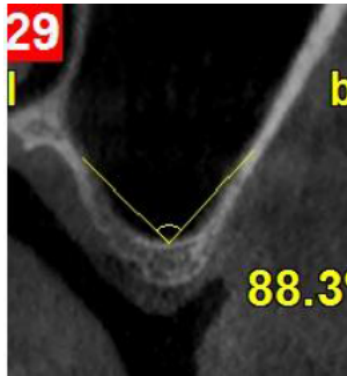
Measuring the angle of Mediolateral walls of the sinus in CBCT cross-sectional image.
